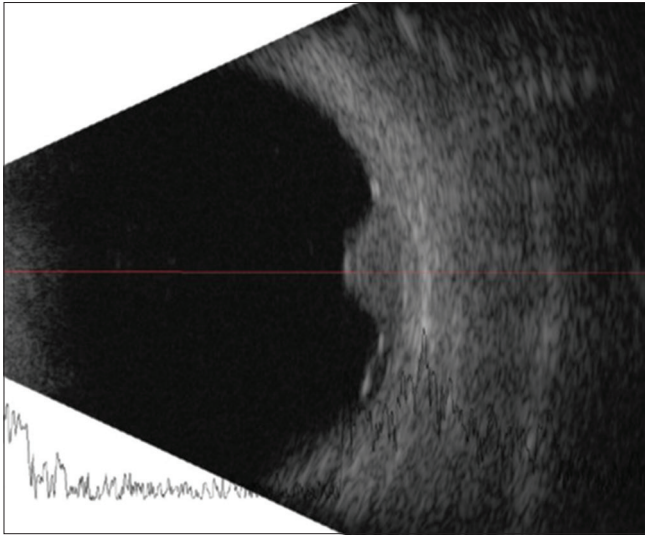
Ultrasound examination revealed a domed shaped choroidal tumor, 2.9 mm in thickness with variable internal reflectivity
